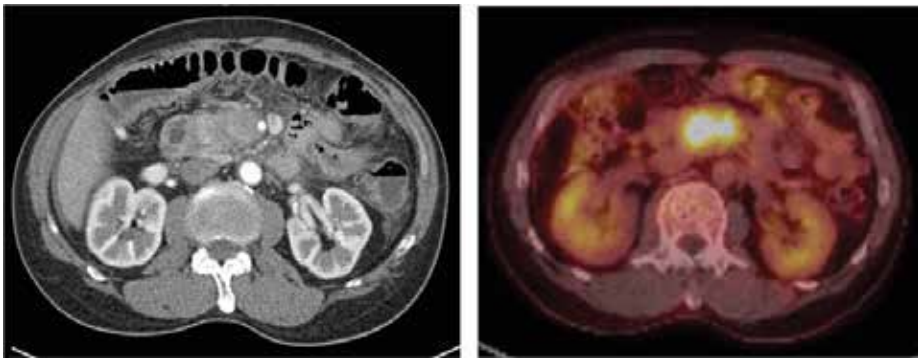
CT and PET scan of pancreatic cancer pre-brachytherapy implantation.
